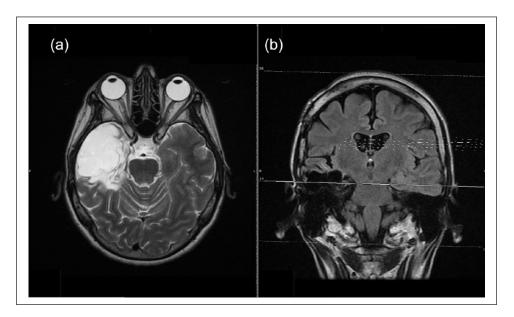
MRI of the brain (a): axial T2 sequence image shows encephalomalacia secondary to the right temporal lobectomy 15 years before the patient's first visit to this clinic and (b) coronal T2 flair sequence image.
